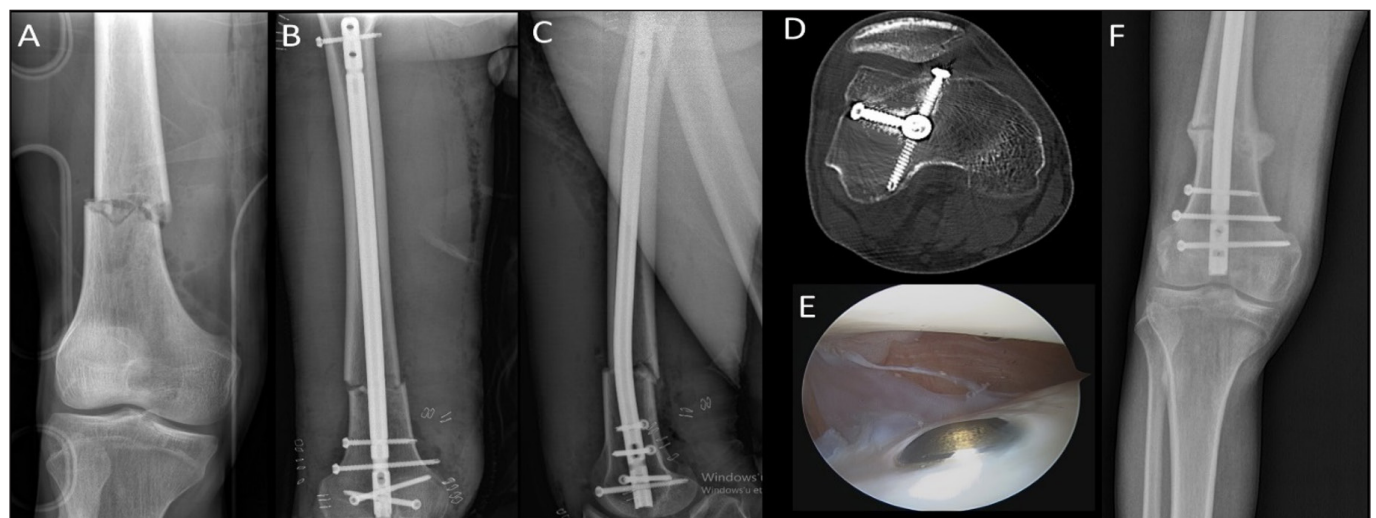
Anteroposterior (A) radiographs of a 30-year-old male patient with a distal femur fracture treated with retrograde intramedullary nailing with a tibial nail (B-C). The patient had persistent knee pain at four-week follow-up. Computed tomography showed an intra-articular screw (D). The patient underwent arthroscopic screw removal (E) and showed fracture healing at six months follow-up (F).
